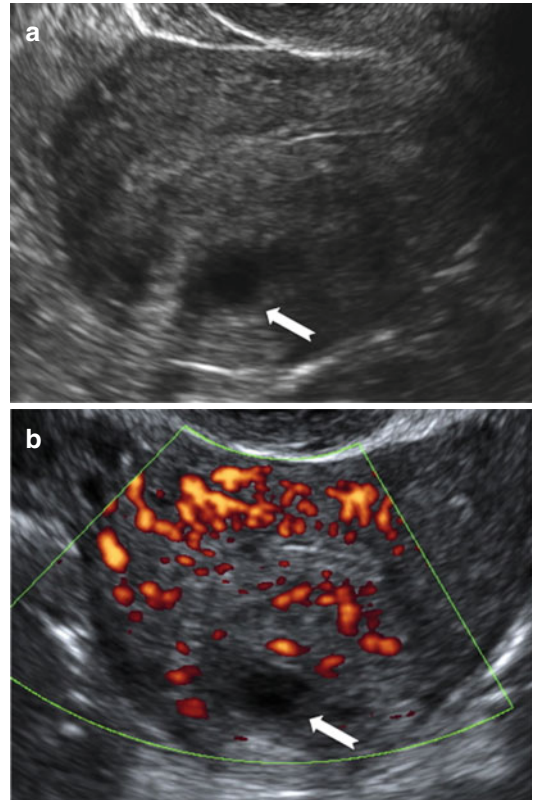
Ultrasound images of a uterus with focal cystic adenomyosis of the posterior wall. (a) Gray scale image showing a cystic anechoic area in the myometrium of the posterior wall (*white arrow*). (b) Power Doppler image showing diffusely spread vessels around the cystic area (*white arrow*)
